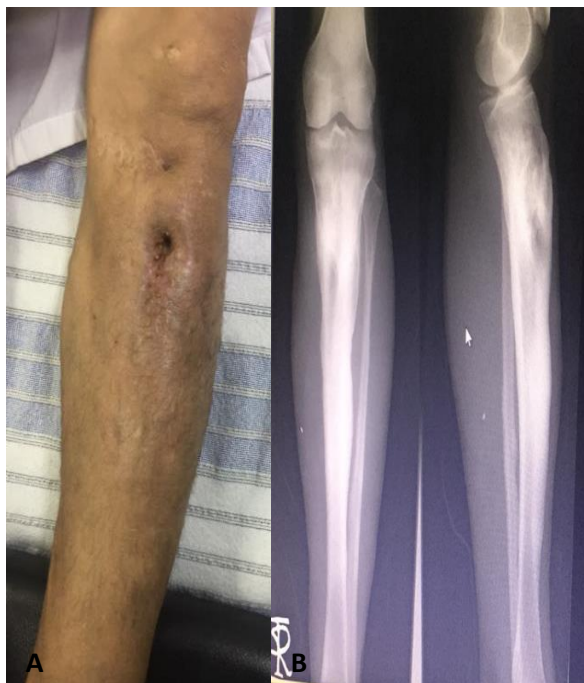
A:Fistulas in the proximal metaphyseal region. B: AP and lateral radiography of the left tibia, lytic area in the tibial metaphyseal region and anterior bone condensation up to the distal diaphyseal region.
